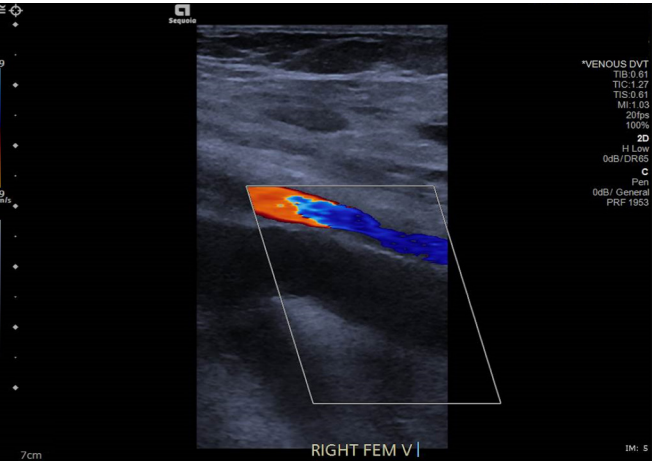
Ultrasound scan image of right femoral vessels: common femoral vein is distended by thrombus and there is absent Doppler flow; normal femoral artery doppler flow. DVT, deep vein thrombosis.
